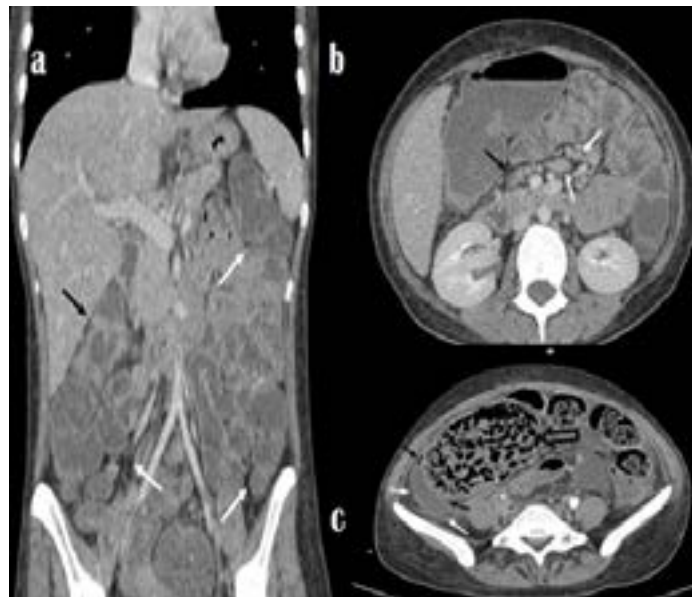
a. Contrast-enhanced coronal CT scan of the abdomen in the portal phase: diffuse dilation of loops of the small intestine and colon (white arrow) and multiple points of intestinal parietal thickening (black arrow). b. Axial section: multiple lymphadenopathies at the root of the mesentery (white arrows) with central necrosis (black arrow). c. Axial view: significant dilation of the cecum (black open arrow), thickening and contrast enhancement - peritonitis (white arrow), and presence of free fluid with intermingled gas foci - pneumoperitoneum (black arrows).
